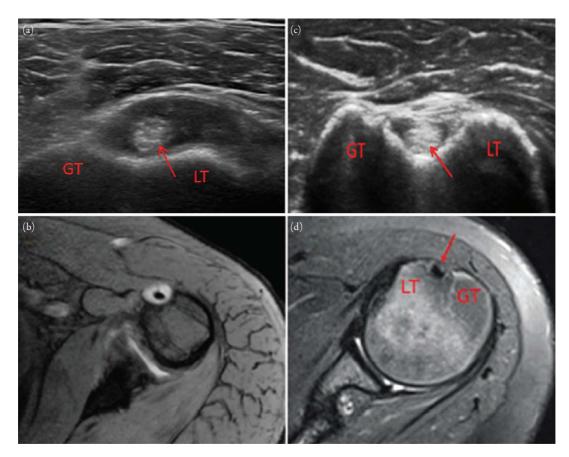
Biceps tendon tenosynovitis. Panel (a) is a grayscale sonographic image in transverse plane of the anterior shoulder showing expansion of the biceps tendon sheath compatible with biceps tenosynovitis in a patient with overlying anterior shoulder pain. The biceps tendon is the oval echogenic structure (arrow) in the intertubercular groove between the greater tuberosity (GT) and lesser tuberosity (LT). Corresponding axial fluid sensitive magnetic resonance image (MRI; Panel (b)) showing the hyperintense (bright) fluid signal surrounding the hypointense (black) biceps tendon in the intertubercular groove. Panel (c) shows a grayscale sonographic image in the transverse plane of the anterior shoulder in an asymptomatic patient with a normal biceps tendon. The biceps tendon sheath is not expaned. Axial fluid sensitive MRI sequence (Panel (d)) of a normal biceps tendon without increased fluid signal surrounding the tendon.
